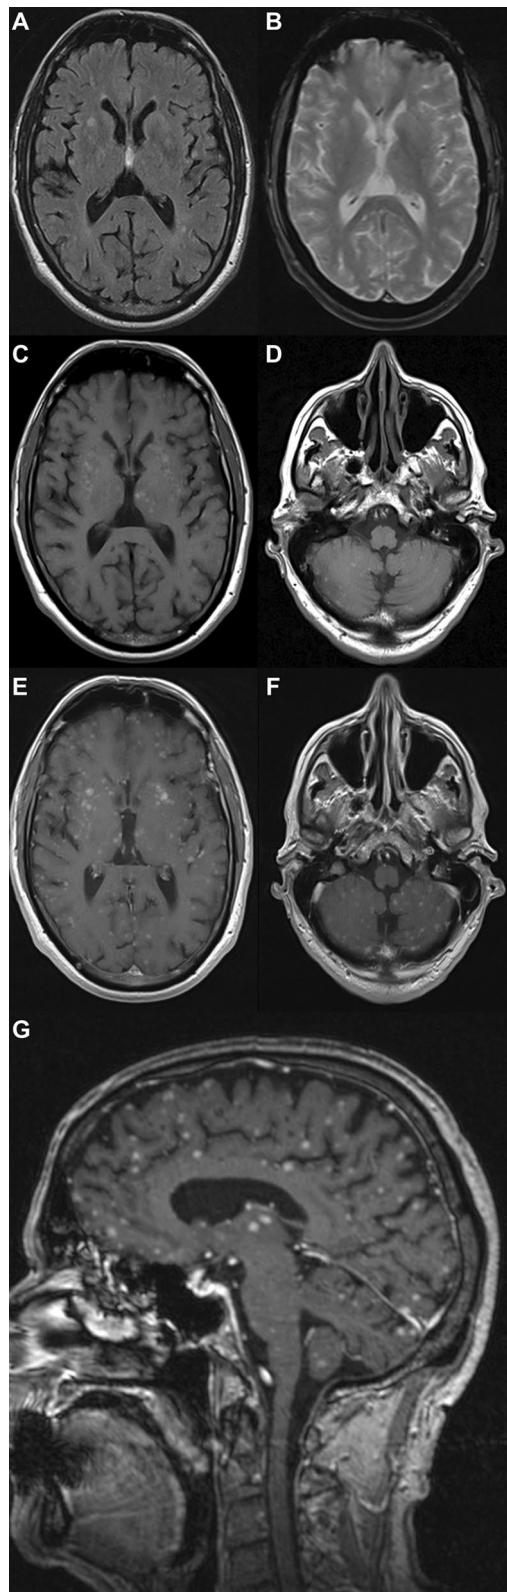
Contrast-enhanced brain magnetic resonance imaging show miliary brain metastases (also called “carcinomatous encephalitis”) from malignant melanoma. A Fluid-attenuated inversion recovery image shows the presence of some hyperintense signal areas, most evident at the level of the basal ganglia. B Fast low-angle shot image shows no brain hemosiderin deposits. C, D Unenhanced Turbo Spin Echo T1-weighted images in supra-tentorial and sub-tentorial regions show the presence of multiple intra-axial hyperintense signal lesions involving also the perivascular spaces, as for melanotic pattern. E, F Enhanced Turbo Spin Echo T1-weighted images in supra-tentorial and sub-tentorial regions show post-contrast impregnation of the multiple intra-axial lesions described in C and D. G Enhanced three-dimension magnetization-prepared rapid gradient-echo T1-weighted image confirms the presence of multiple intra-axial supra- and sub-tentorial lesions with post-contrasts impregnation; the cervical spinal cord included in the study shows no signal alterations
